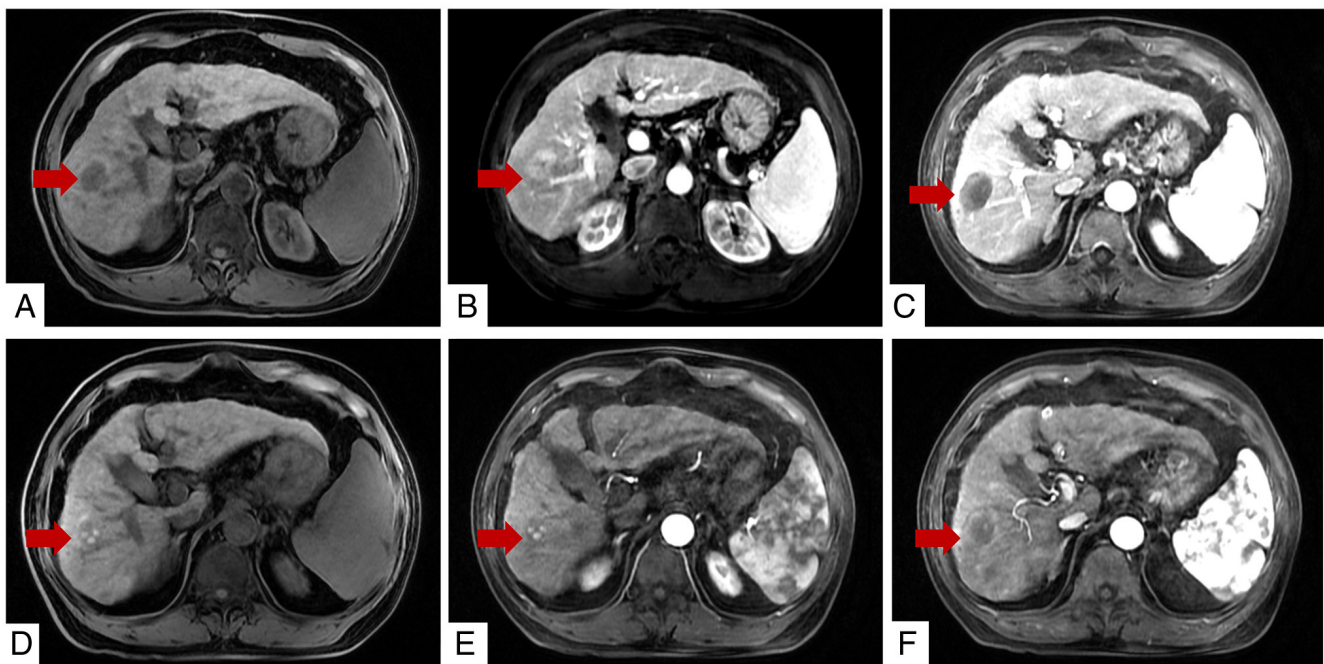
Comparison of pre- and post-treatment MRI of a patient undergoing combination therapy. (A) Baseline T1-weighted image shows a new lesion in the right lobe of the liver. (B) Baseline arterial-phase contrast-enhanced MRI shows typical arterial hyperenhancement of the lesion. (C) Baseline portal venous-phase image shows washout. (D) At 1 month after microwave ablation combined with immunotherapy, follow-up T1-weighted image shows the treated lesion/ablation zone. (E) Follow-up arterial-phase image shows no notable enhancement. (F) Follow-up portal venous-phase image also shows no notable enhancement.
